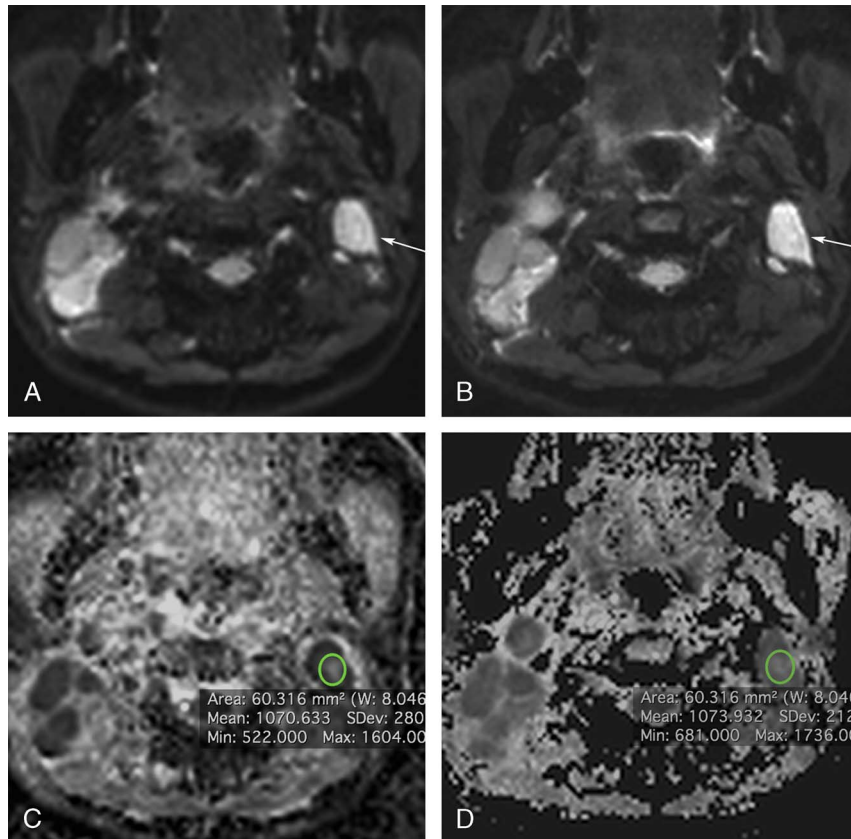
A 42-year-old male patient with diagnosed NPC and bilateral cervical lymph node enlargement. The left level II cervical lymph node was proved metastasis by biopsy pathology (white arrow). The SMS-RS-DWI technique (B) shows improved image quality and more clearly lesion edge compared with RS-DWI (A). The ADC maps of RS-DWI (C) and SMS-RS-DWI (D) show focal low signal intensity of the given lymph node with similar ADC value (green circle). Figure 4 can be viewed online in color at www.jcat.org.
